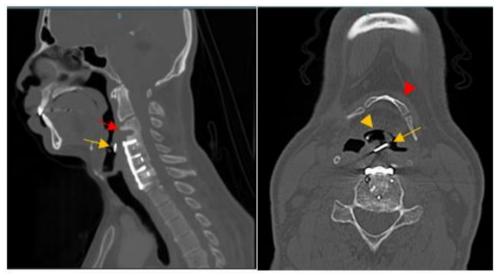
Sagittal and Axial Computed Tomography of the neck, showing signs of previous arthrodesis of the cervical spine from C3-C7, and absence of the Cage Device used between the levels of C3-C4, with apparent displacement of the device, projecting itself over the supraglottic region, causing partial larynx obstruction; Red arrow = empty vertebral space after displacement of cage
